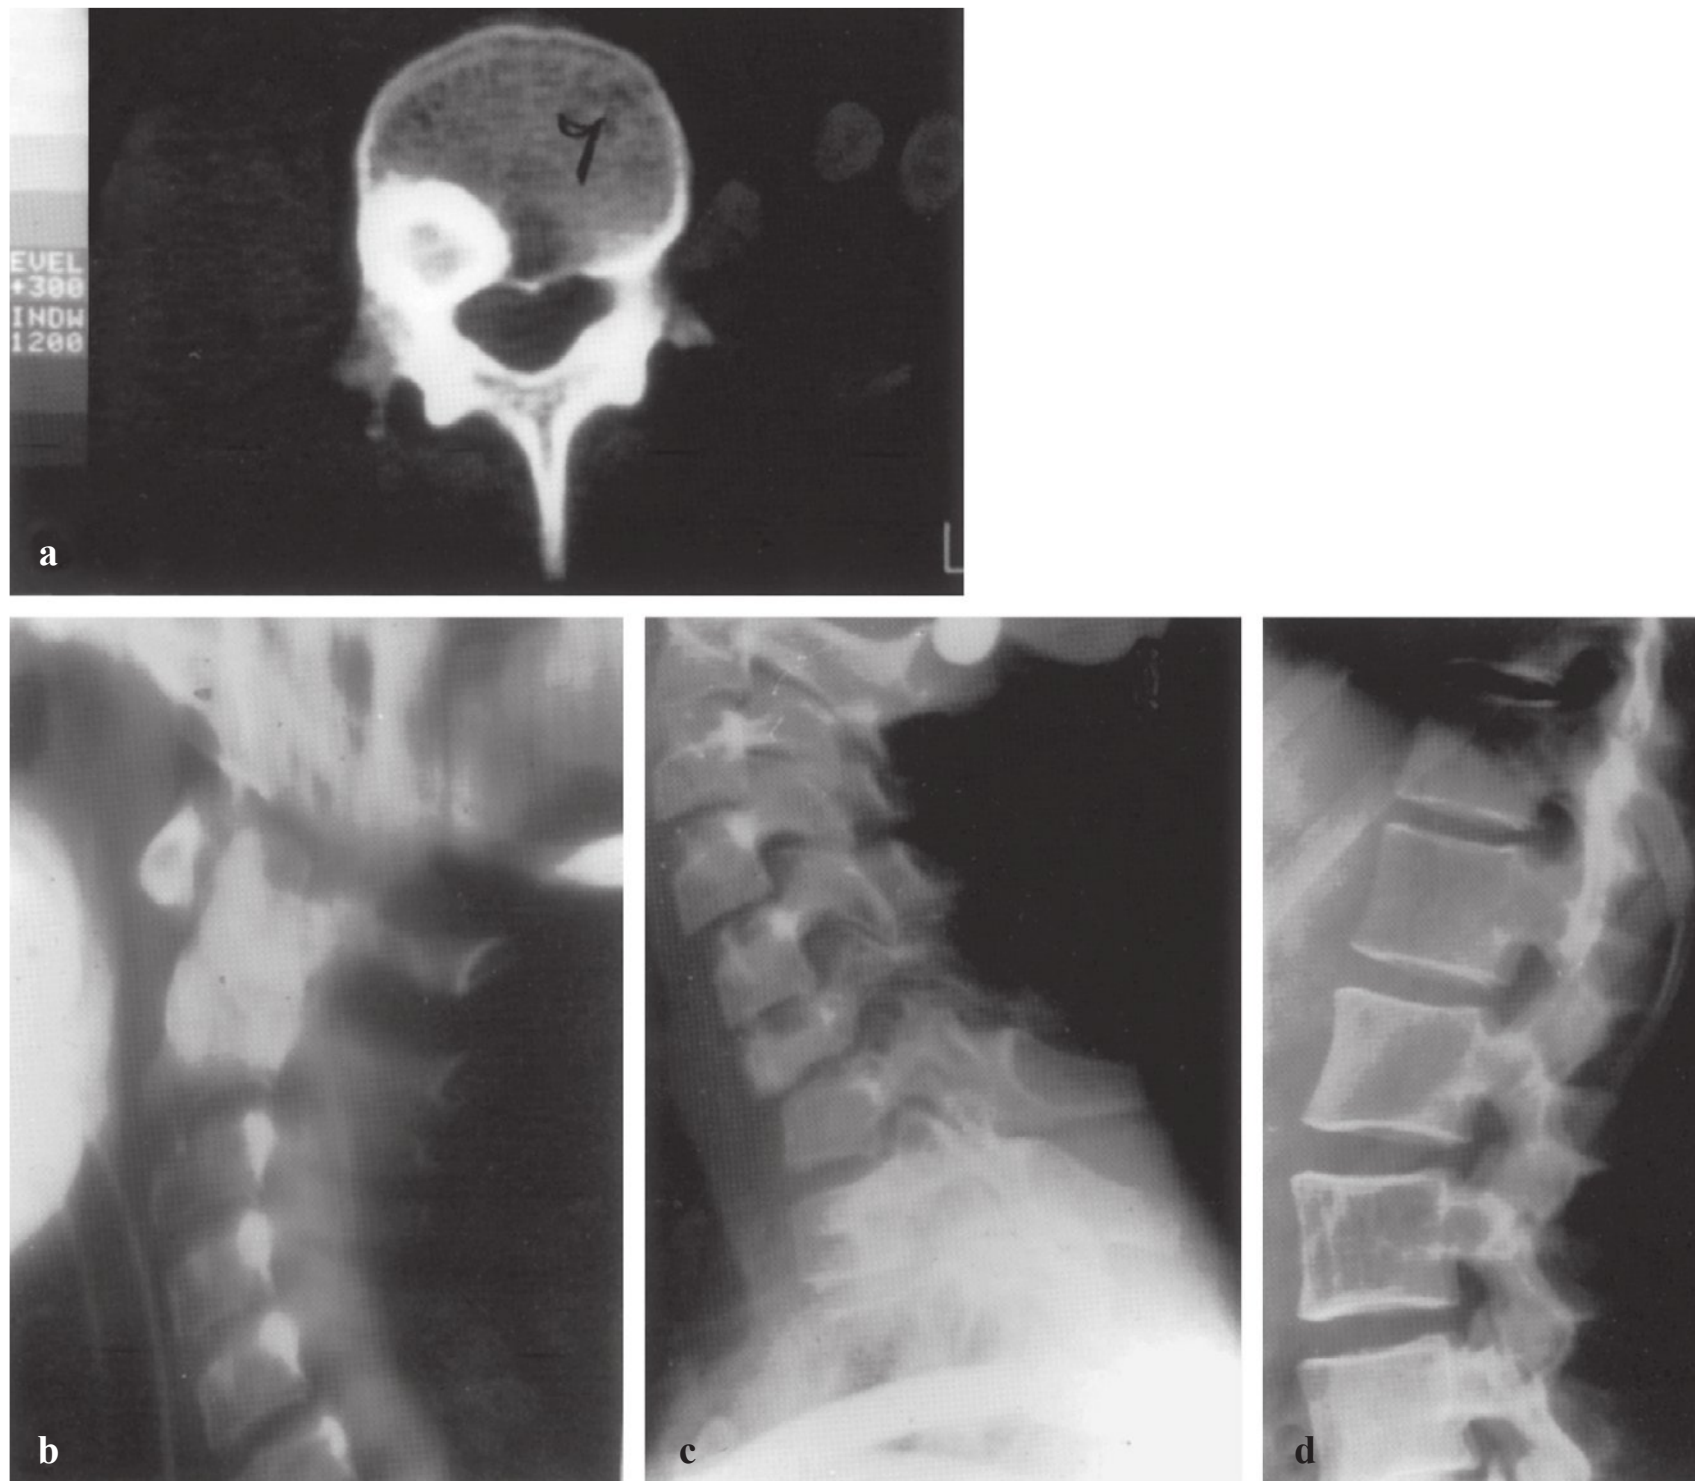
Examples of primary benign tumors of the spine. (a) Computed tomography (CT) scan demonstrating an osteoid osteoma with a central nidus and sclerotic rim at the posterior part of the vertebral body. (b) Lateral radiograph demonstrating an osteoblastoma of C2 with an expansile sclerotic bone. (c) Lateral radiographs demonstrating vertebra plana at C6 due to eosinophilic granuloma. (d) Lateral lumbar radiograph showing a hemangioma with osteopenia and vertical striations of the vertebral body.
